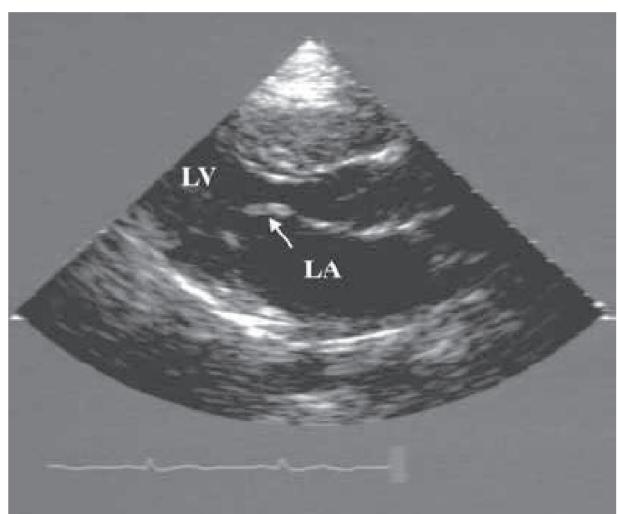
Stop frame of a two-dimensional echocardiogram from a patient with mitral stenosis in the parasternal long axis at onset of diastole showing the typical bowing of the anterior mitral leaflet (arrow).
